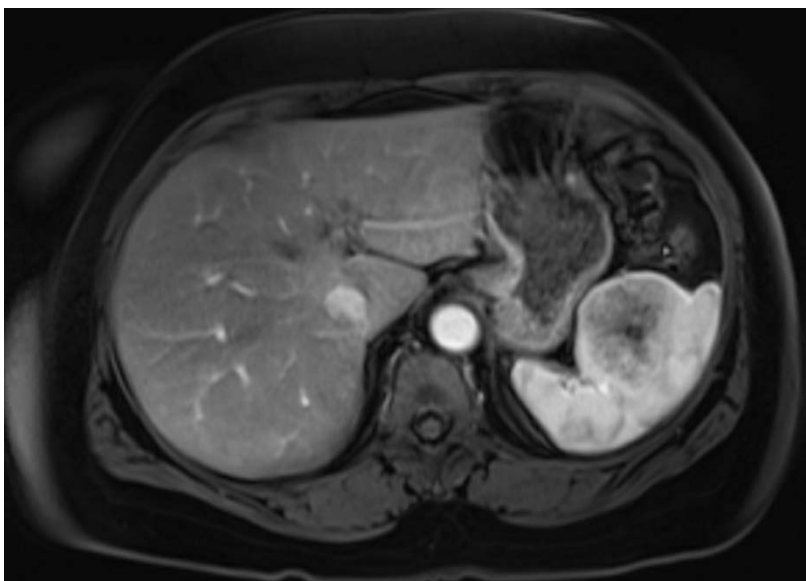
MRI of splenic mass - T2 – weighted
